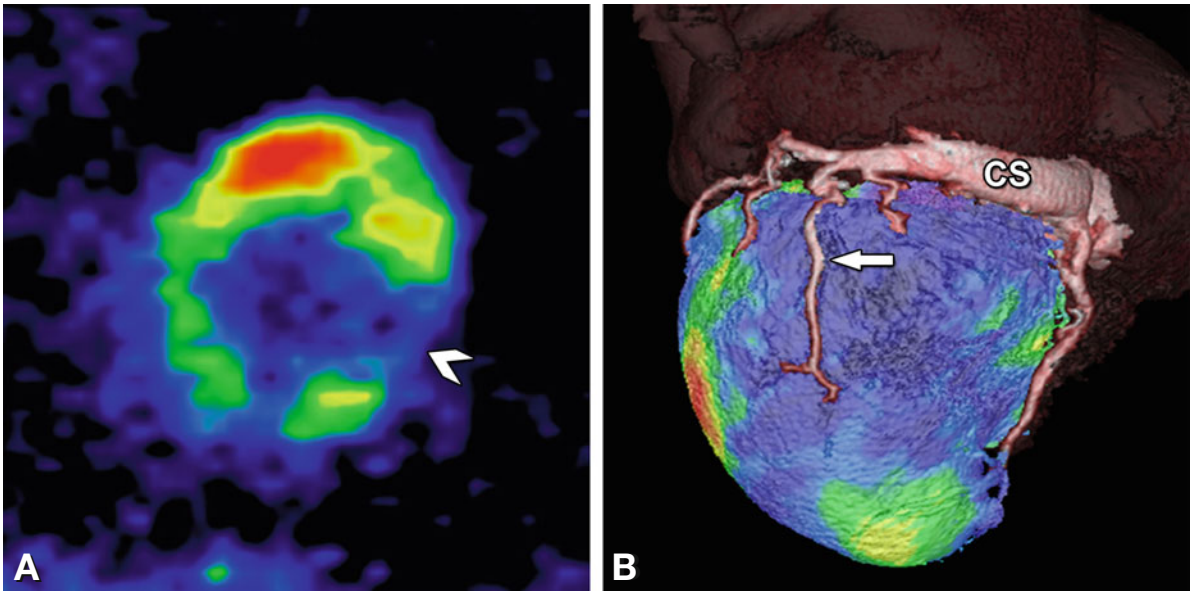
Hybrid FDG PET/CT venous angiogram in a patient with ischemic cardiomyopathy, reduced left ventricular function and congestive heart failure. FDG PET showed a nonviable scar in the inferolateral wall (*arrowhead in Panel A*, short-axis slice) while viability in the anterior wall appeared to be preserved. On PET/CT, a large posterolateral vein can be seen which appears suitable for percutaneous lead insertion of a cardiac resynchronization therapy device (*arrow in Panel B*, volume rendering view from below), however, viability in the target territory is reduced, questioning whether this particular patient will benefit from such therapy. CS coronary sinus
